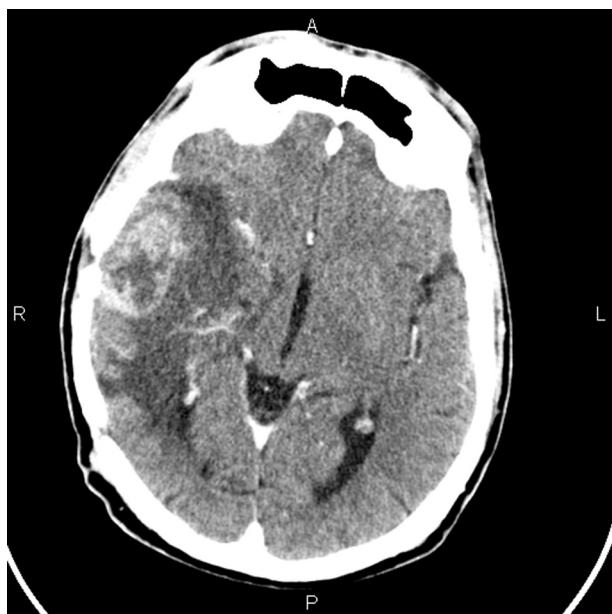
CT scan of recurrence tumor.
